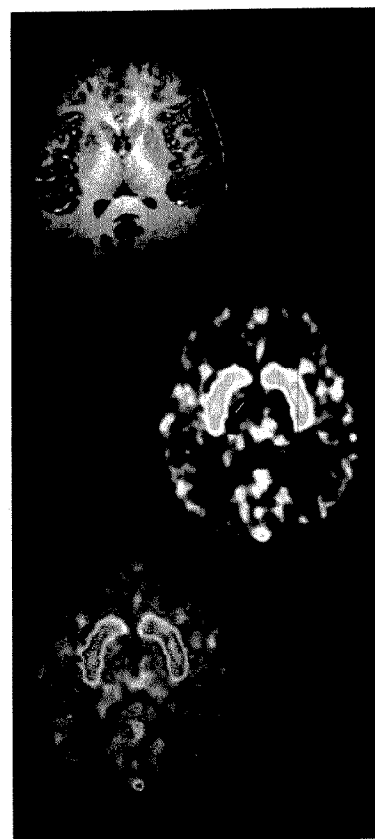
The image shows the MRI image of the brain on the top and the PET image of the same person in the center. The image at the bottom is the fused image showing the receptor density of the dopamine D2 receptors overlaid on the anatomical image. (Courtesy of Dr. Gene-Jack Wang and Aarti Kriplani)
